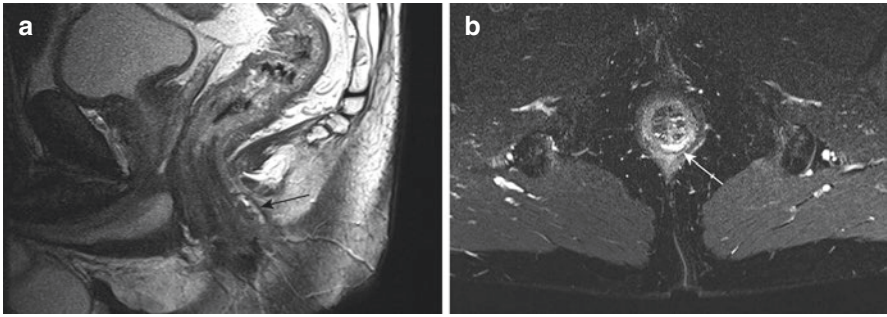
An intersphincteric tract (arrow) on a sagittal T2-weighted sequence (a) and oblique axial T2-weighted fat-suppressed sequence (b)
